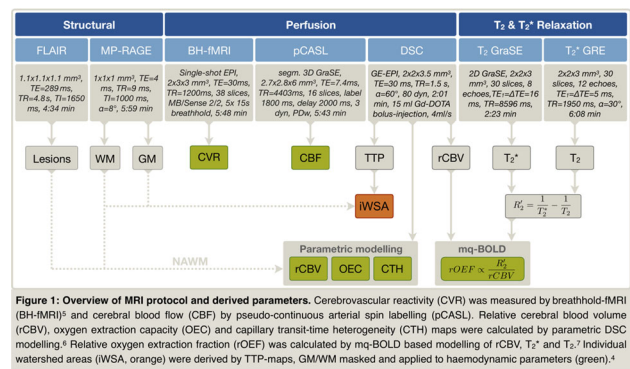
Overview of MRI protocol and derived parameters. Cerebrovascular reactivity (CVR) was measured by breathhold-MRI (BH-MRI) and cerebral blood flow (CBF) by pseudo-continuous arterial spin labelling (pCASL). Relative cerebral blood volume (rCBV), oxygen extraction fraction (OEF) and capillary transit-time heterogeneity (CTH) maps were calculated by parametric DSC modelling.<sup>4</sup> Relative oxygen extraction fraction (rOEF) was calculated by mq-BOLD based modelling of rCBV, T2\* and T2.<sup>7</sup> Individual watershed areas (WSA, orange) were derived by TTP-maps, GMMW masked and applied to haemodynamic parameters (green).<sup>4</sup>
